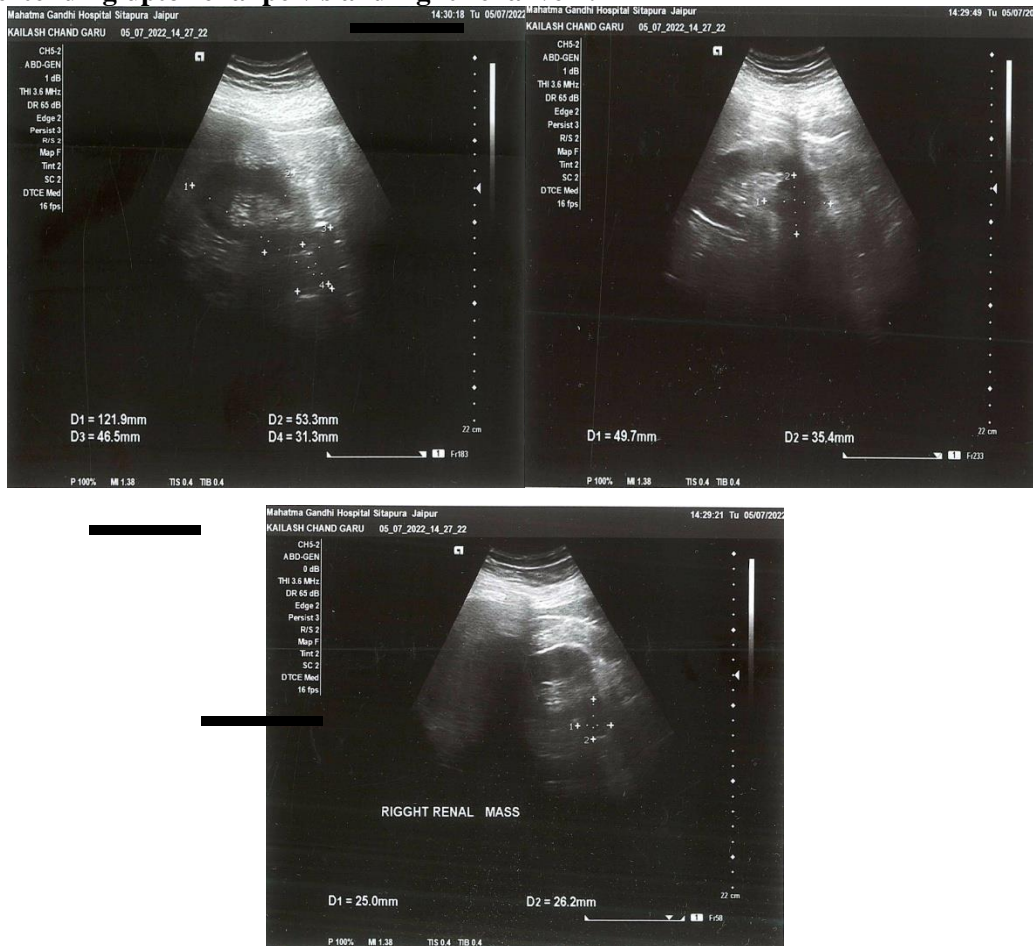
Ultrasonography shows round to oval mass lesion with heterogenous echotexture and internal vascularity in the lower pole, extending upto renal pelvis and right renal vein.
